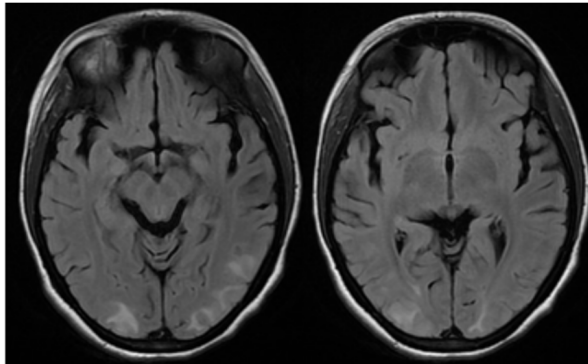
Near symmetrical bilateral T2/ FLAIR hyper intensities seen in parieto-occipital, right frontal and left temporal lobe cortex and subcortical white matter features suggestive of Posterior Reversible Encephalopathy Syndrome (PRES).
